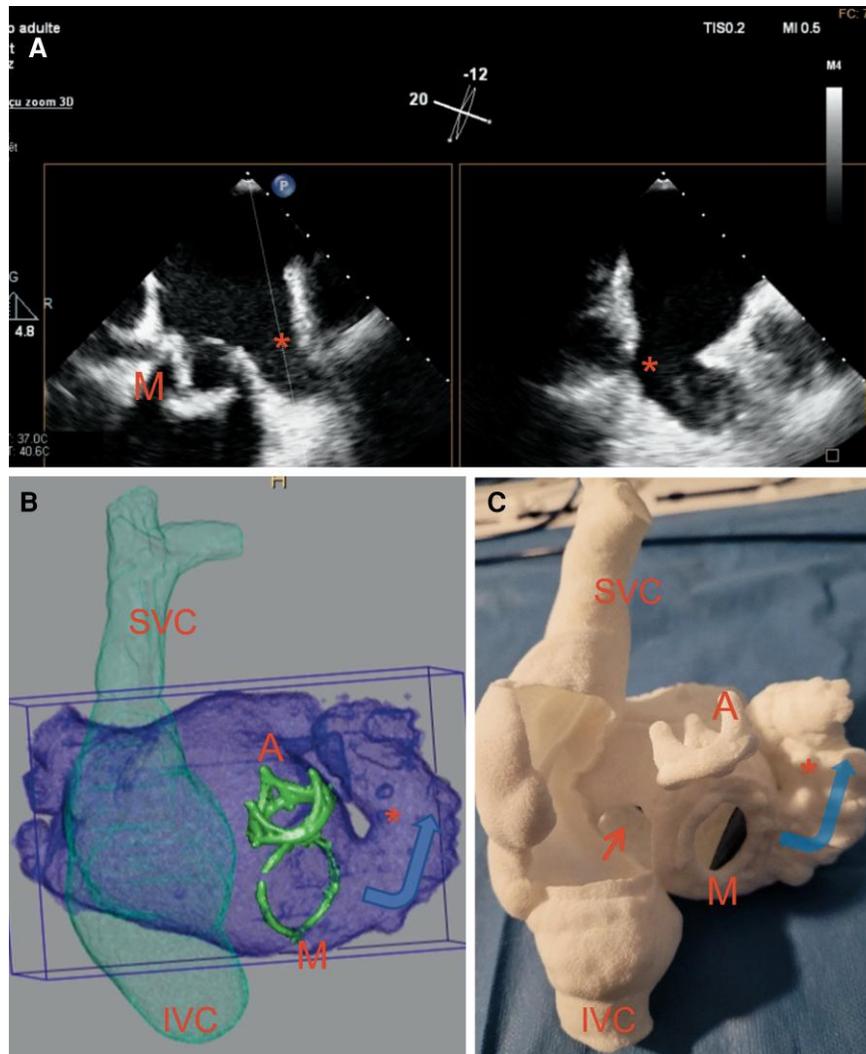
Pre-procedure imaging. (A) Biplane TEE view showing a large LAA(*) ostium close to the mitral prosthesis ring (M). Owing to the low position, the usual landmarks (such as the circumflex artery) are absent. (B) Pre-procedure CT scan: volume rendering of the left atrium in purple, right atrium in transparency green shell, including inferior (IVC) and superior vena cava (SVC). Note that mitral (M) and aortic (A) prostheses are superimposed in using volume rendering filled to remark the horn-like shape of the LAA with basal insertion and directed upwards (blue arrow). (C) SLS 3D-printed model with exact representation of the left atrium, right atrium which is sectioned in order to see the orifice corresponding to the thin inter atrial septum (red arrow). Note the aortic and mitral bioprotheses.
